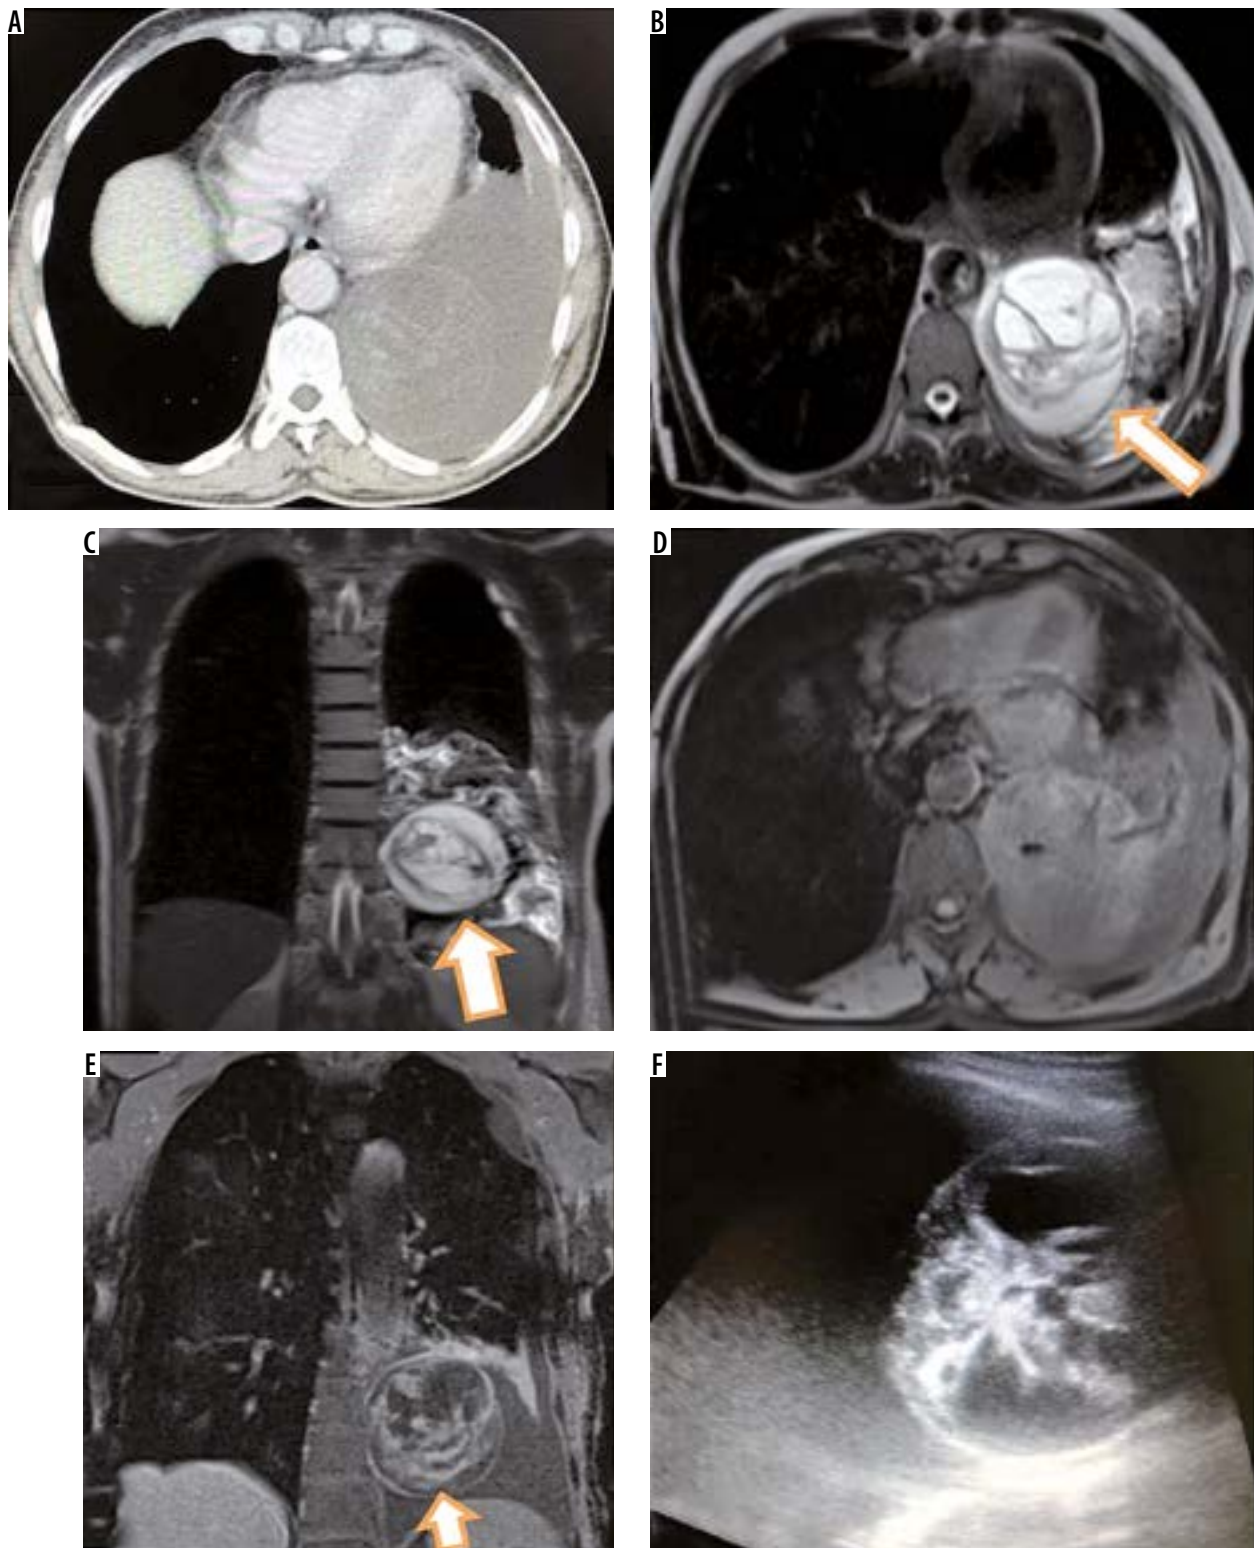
Axial computed tomography image (A) of a middle aged man showing round hypodense lesion in left lower lobe with pleural effusion. Corresponding T2-W magnetic resonance images (MRI) in axial (A) and coronal plane showing hypointense wall (arrow in B) with intralésional hypointense membranes or septations (arrow in C) suggesting hydatid cyst. Axial T1-W MRI (D) shows isointense to muscle lesion. Post-contrast T1-W coronal image (E) shows enhancement of wall and internal septations. USG was done which revealed round lesion with both solid and cystic components (F). Patient was operated and biopsy showed cystic schwannoma
